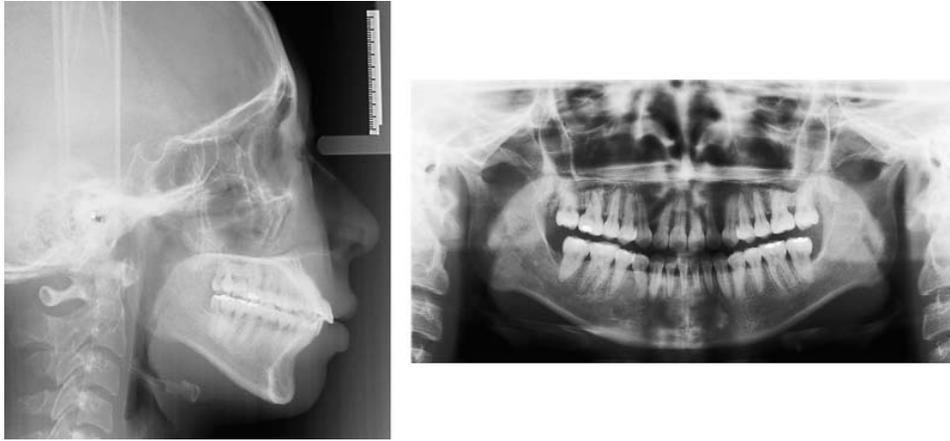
Posttreatment cephalogram and panoramic radiograph.
